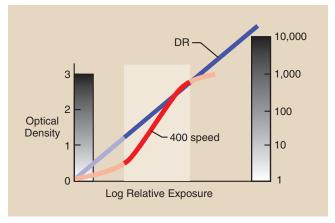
Response of a screen-film and a digital image receptor. The emphasized range is that normally chosen for screen-film exposure. The digital radiography image receptor can receive essentially any radiation exposure.
